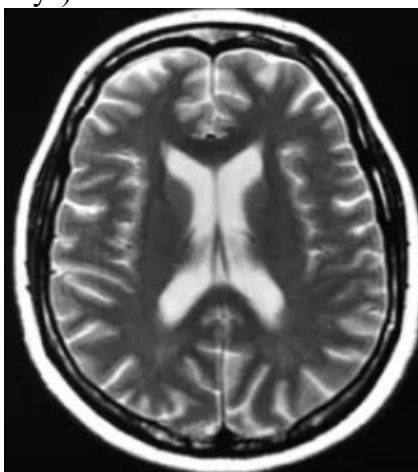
Cerebral MRI (axial T2 sequence) – with no pathological findings
